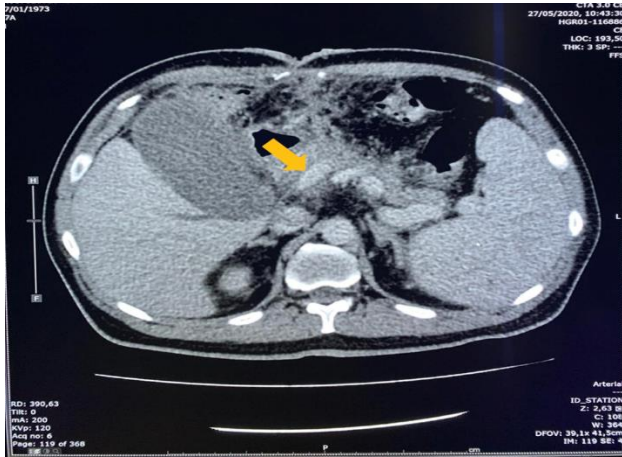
Postoperative abdominal CT with IV contrast, it is indicated where atrophic pancreas is observed, without collections.
